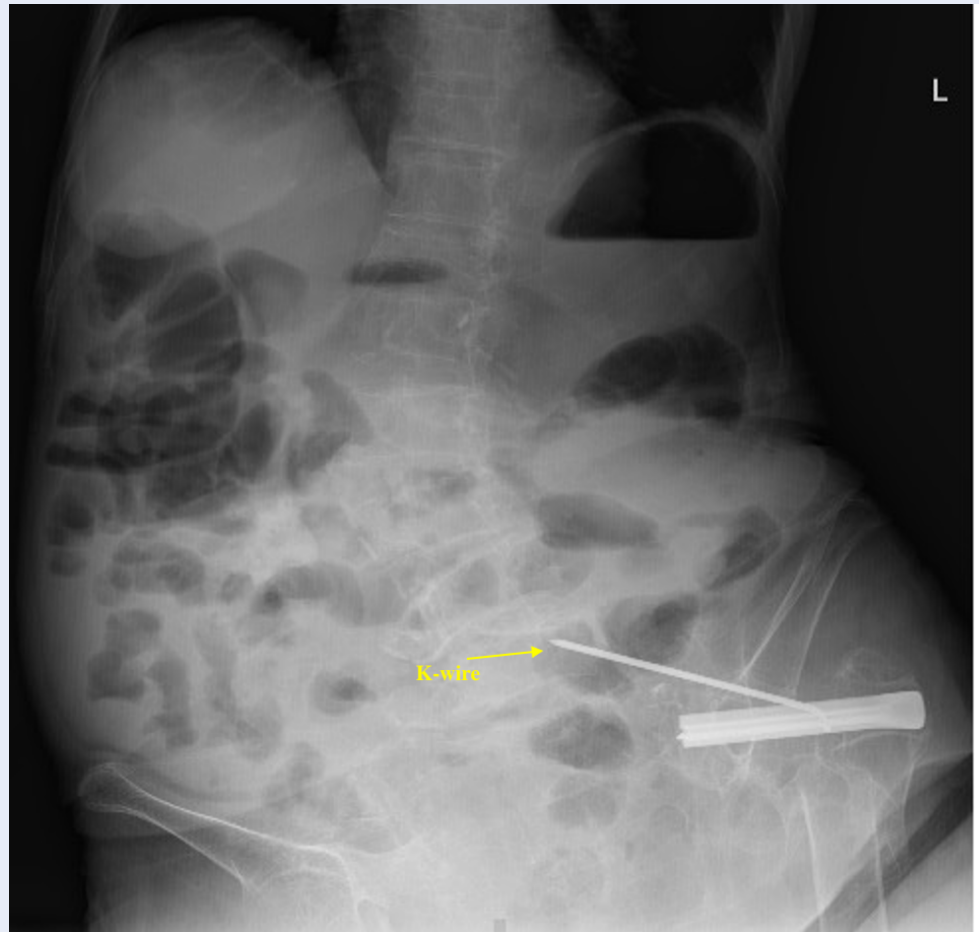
Abdominal radiography shows that the K-wire has shifted from its original position (yellow arrow).
